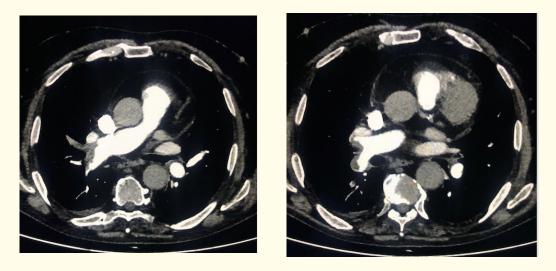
Images of computed tomographic angiography.
